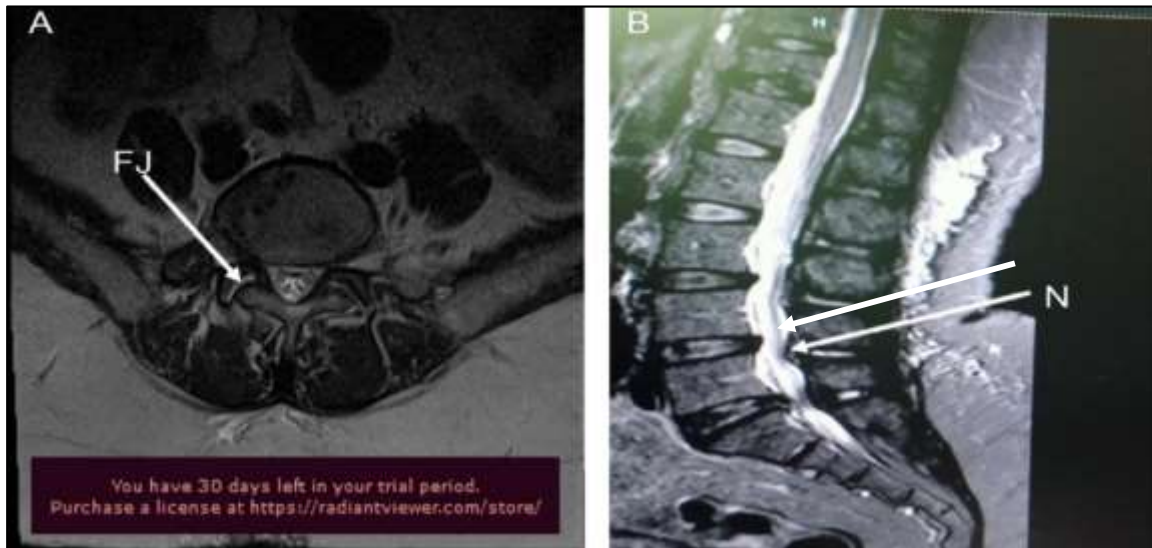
MRI sagittal view of the lumbar spine showing facet joint effusion and Spinal canal narrowing.
